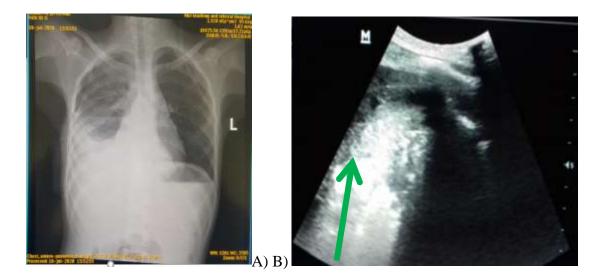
(A case of abnormal CXR and LUS) A 4-year-old male, presented with clinical diagnosis of pneumonia. A) CXR demonstrated right sided pleural effusion A) lung ultrasound demonstrates pleural effusion.
